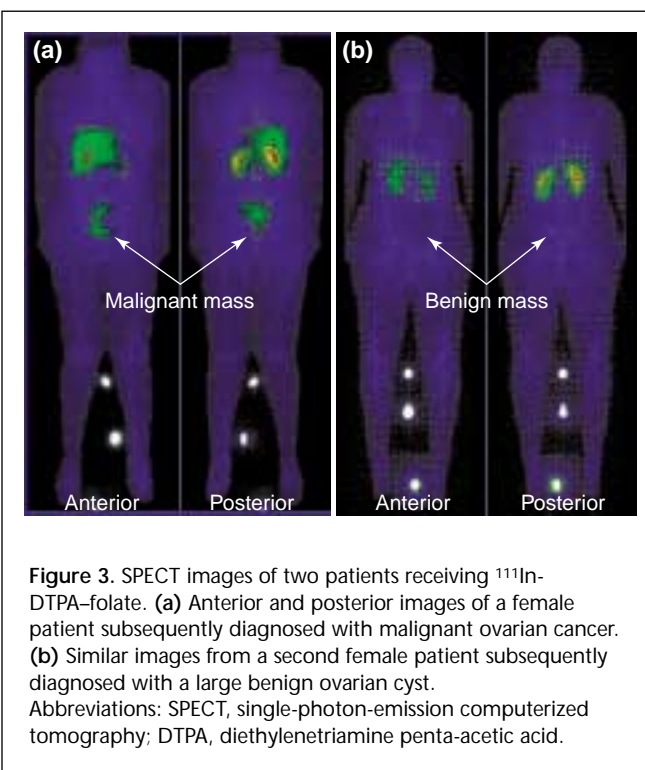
SPECT images of two patients receiving ¹¹¹In-DTPA-folate. (a) Anterior and posterior images of a female patient subsequently diagnosed with malignant ovarian cancer. (b) Similar images from a second female patient subsequently diagnosed with a large benign ovarian cyst. Abbreviations: SPECT, single-photon-emission computerized tomography; DTPA, diethylenetriamine penta-acetic acid.
